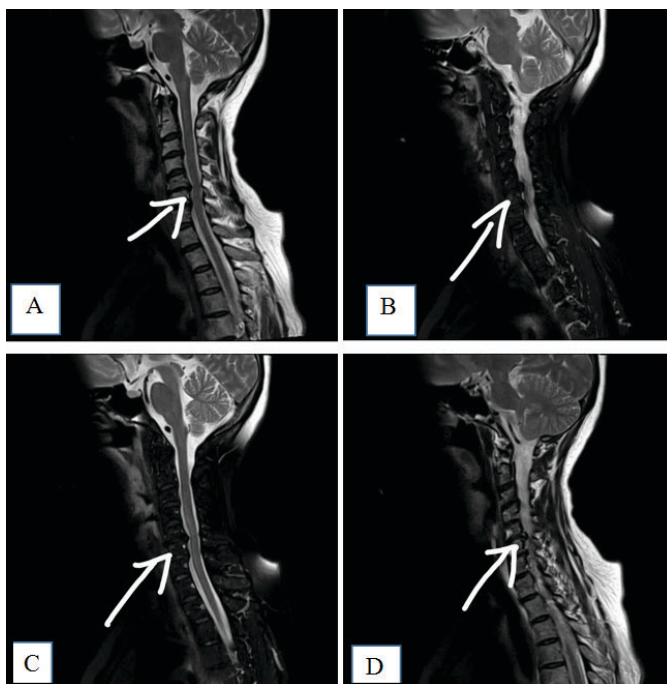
Sagittal T2W MRI images of cervical spine showing disc space narrowing and herniation of C5-6, C6-7 with resultant central canal narrowing which is more obvious on left side with no cord signal changes.
